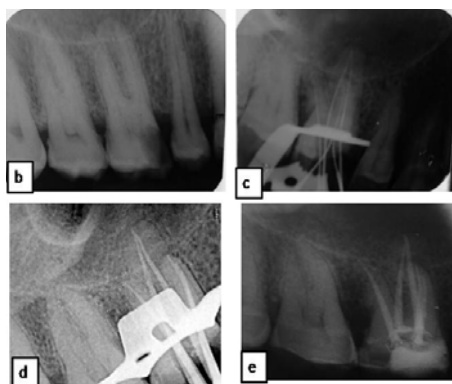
(b) Pre-operative view; (c) Working length; (d) Master cone; (e) Obturation radiographs
